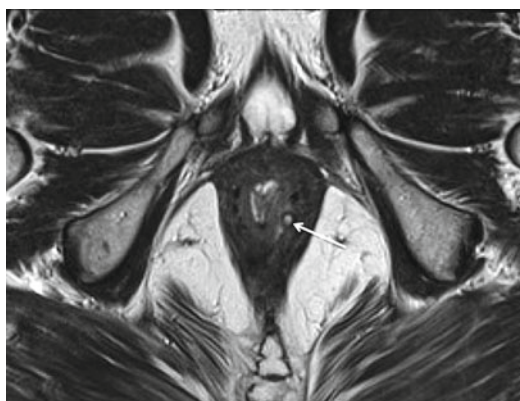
Axial T2-weighted MR images in a man with an intersphincteric fistula (arrow). Note that the fistula is contained by the external sphincter; there is no sepsis in the ischioanal fossa
